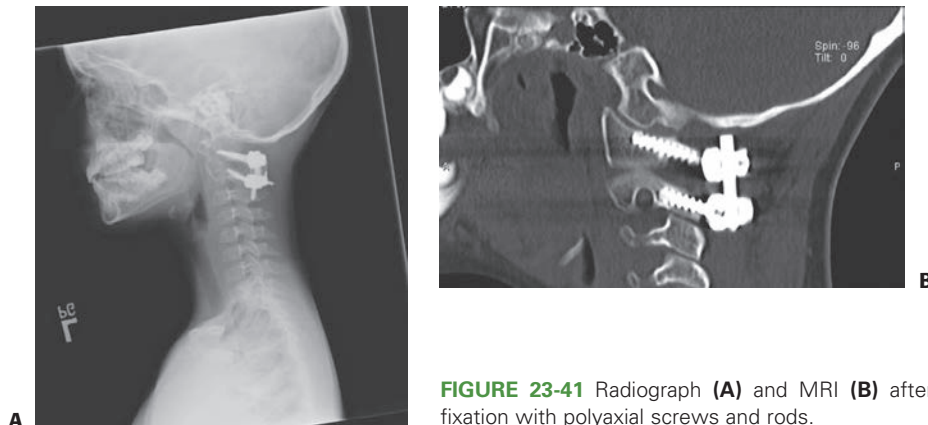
Radiograph (A) and MRI (B) after fixation with polyaxial screws and rods.
